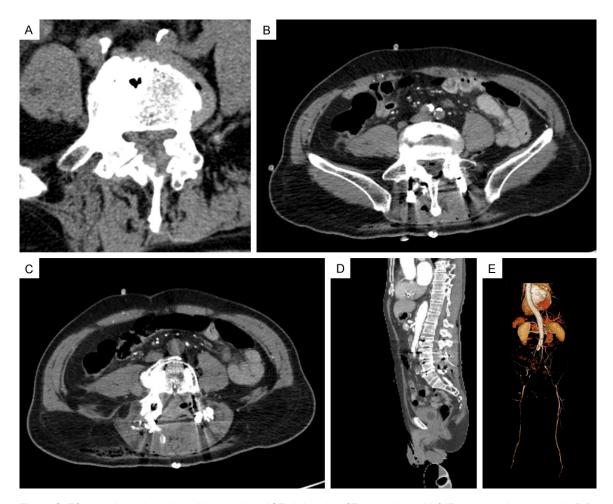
79-year-old male patient diagnosed as ASE. A: Lumbar CT scan showed L4/5 severe spinal stenosis. B-D: The emergent CTA showed no blood supply in abdominal aorta and bilateral iliac arteries after laminectomy. E: The 3-D reconstruction of CTA showed the severe embolization of abdominal aorta and bilateral iliac arteries.
